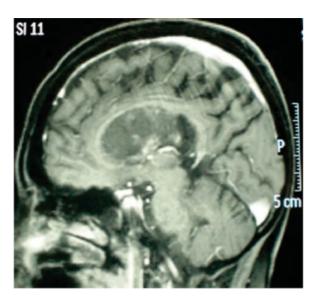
A sagittal section of contrast-enhanced T1-weighted magnetic resonance imaging showing evidence of corpus callosum and of a solid-cystic intraventricular lesion with 6.1 cm of anteroposterior length.
